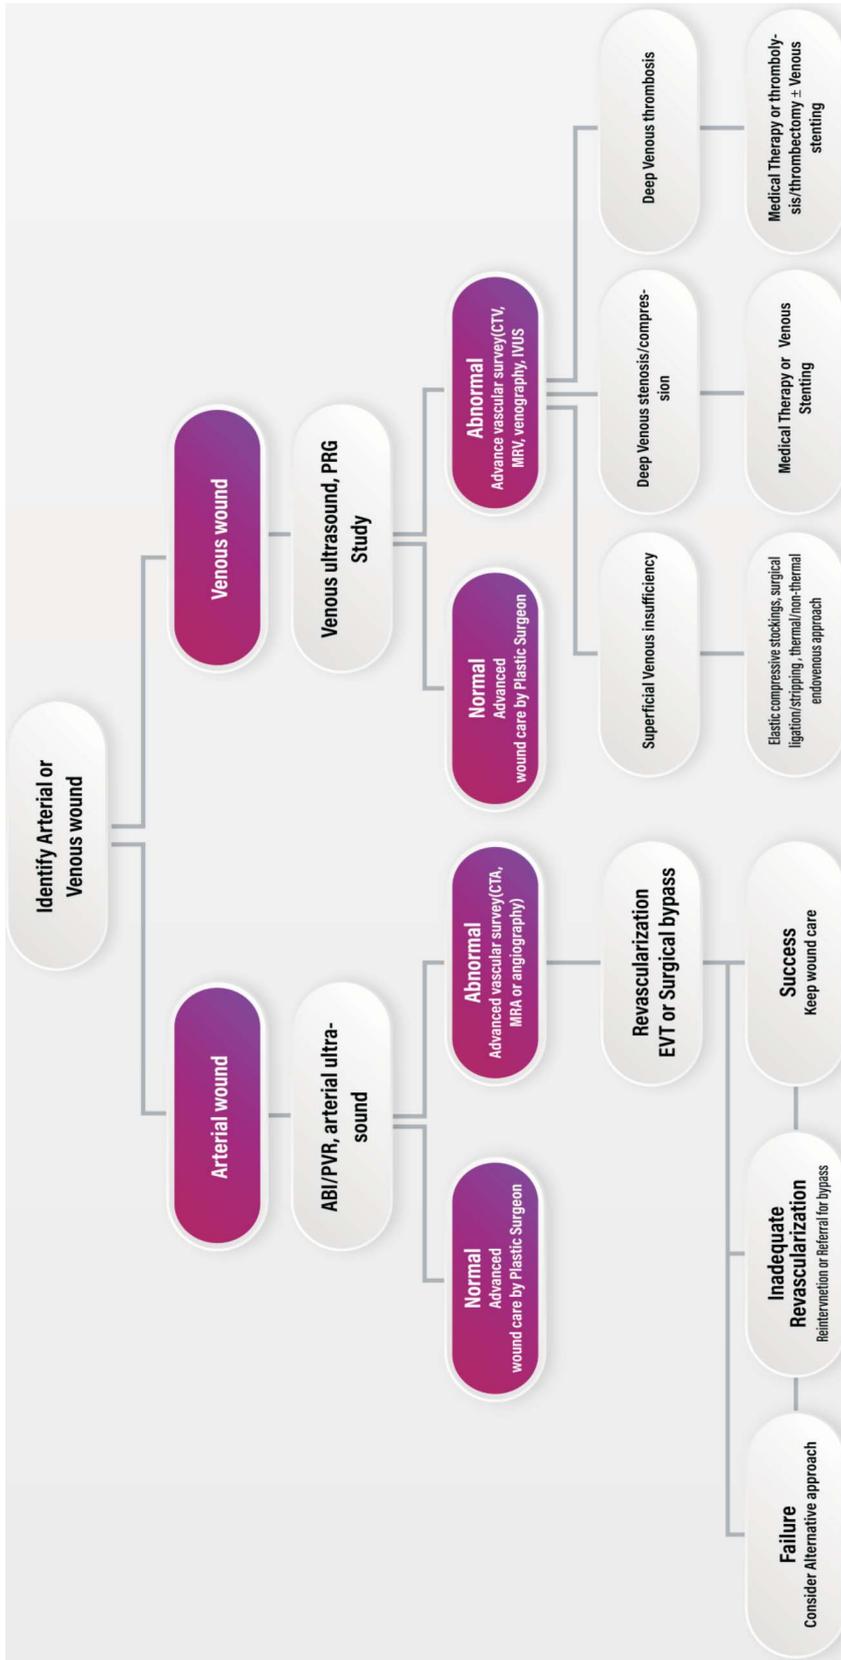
Distinct treatment algorithms for arterial and venous wounds. Left side of the figure details the treatment algorithm for arterial wounds, emphasizing the importance of restoring blood flow, addressing ischemia, and managing underlying arterial disease. It outlines steps ranging from initial assessment to advanced surgical interventions, tailored to the specific challenges of arterial wound healing. Right side of the figure presents the treatment algorithm for venous wounds. This algorithm focuses on improving venous return, managing edema, and treating venous insufficiency. It includes strategies such as compression therapy, wound debridement, and possibly surgical correction of venous pathology. ABI, ankle-brachial index; CTA, computed tomography angiography; CTV, computed tomography venography; EVT, endovascular therapy; IVUS, intravascular ultrasound; MRA, magnetic resonance angiography; MRV, magnetic resonance venography; PRG, phleboreography; PVR, pulse volume record.
